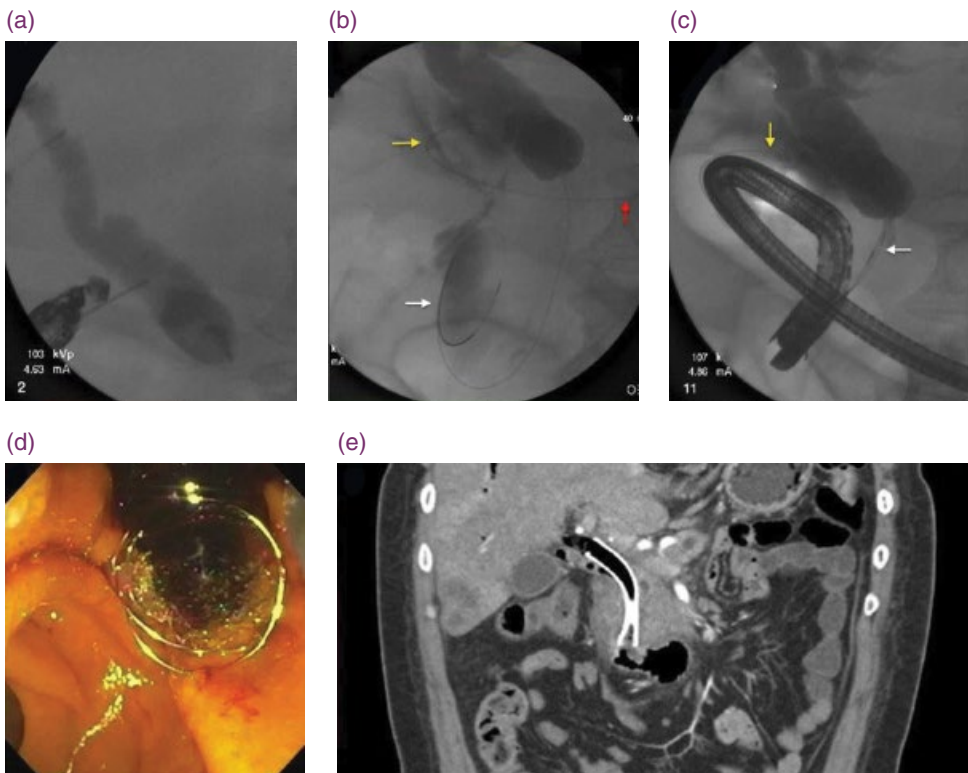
Endoscopic ultrasound guided biliary drainage using the rendezvous technique. (a) The common bile duct (CBD) was punctured with a 19 gauge needle under endosonographic guidance, and antegrade cholangiography revealed a dilated CBD with distal obstruction. (b) Antegrade passage of the guidewire can be seen passing via the stomach (red arrow), duodenal bulb (yellow arrow), through the papilla, and coiled in the distal duodenum (white arrow). (c) The wire was grasped through a duodenoscope and a sphincterotome was passed over the wire (white arrow). The wire was withdrawn from the duodenal bulb (yellow arrow) and readvanced in a retrograde fashion to facilitate transpapillary stent placement. (d) Dark bile flowing through transpapillary self-expandable metallic biliary stent. (e) Coronal computed tomography image showing a self-expandable metallic stent placed across a distal biliary stricture due to a pancreatic mass.
